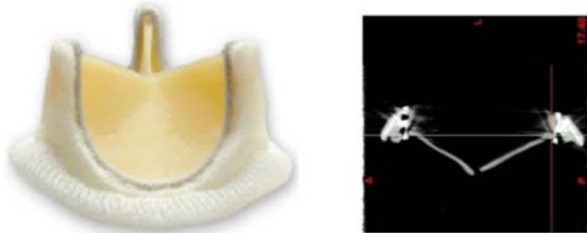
(a) Carpentier-Edwards PERIMOUNT aortic heart valve. (b) μ CT scan of the prosthetic device
